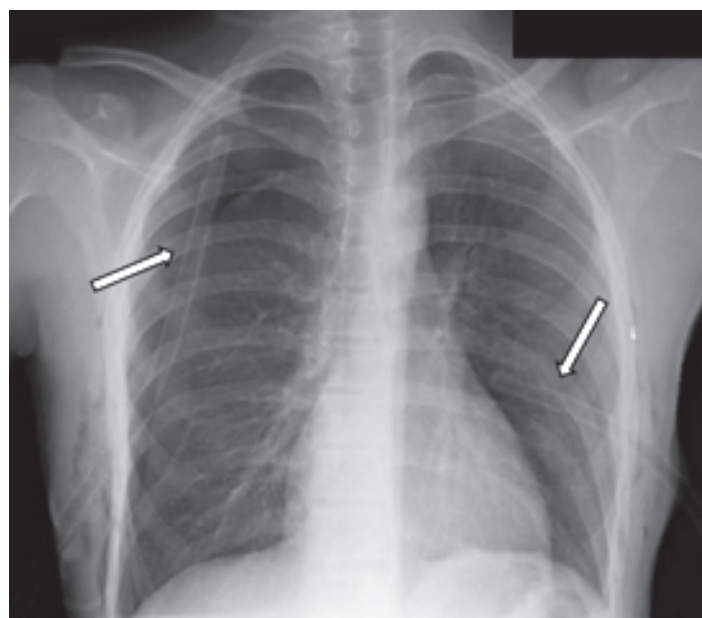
Postero-anterior radiograph of the chest shows interval placement of bilateral chest thoracostomy tubes with complete re-expansion of the left lung and partial (~70%) re-expansion of the right.
